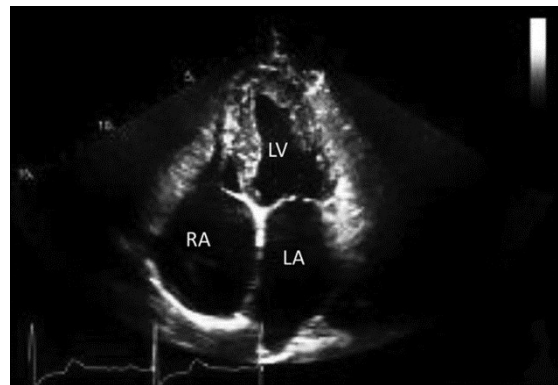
Echocardiography RCM, apical view
